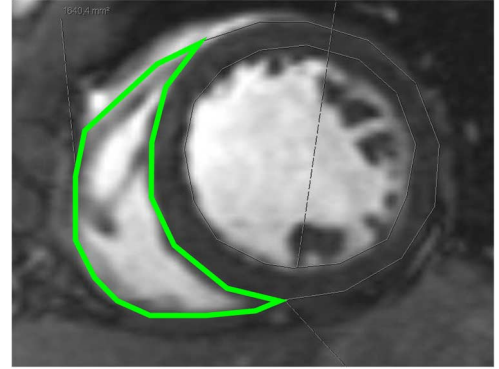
Example of manual segmentation in MRI short axis view.
